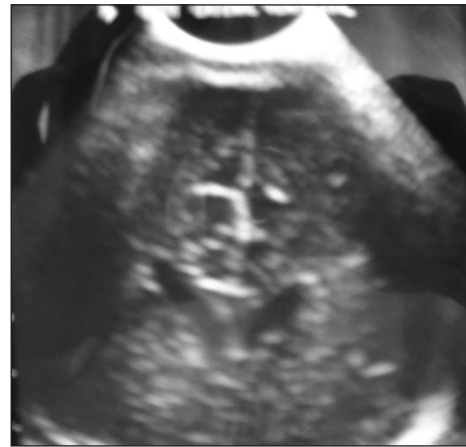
Brain sonography showing early stage of dilated ventricle
